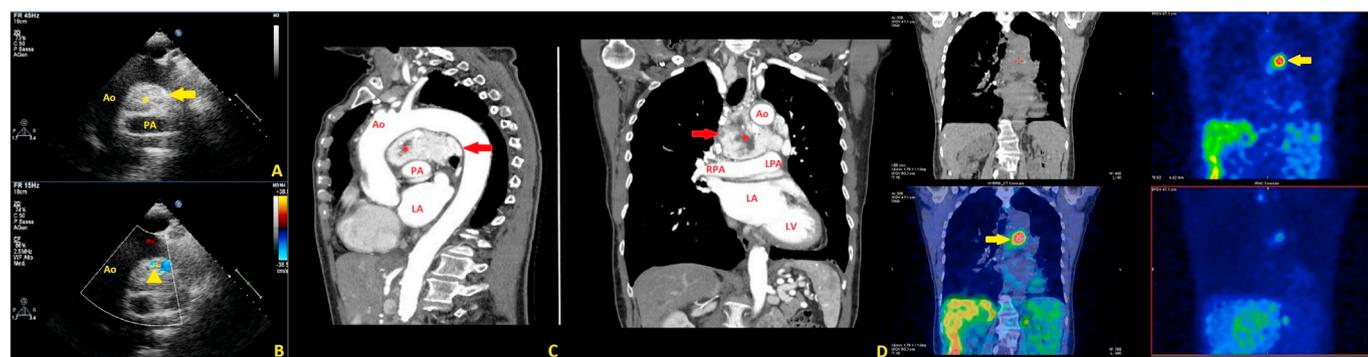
Transthoracic echo (suprasternal window) showing a hypoechoic mass (yellow arrow) with a central hyperechoic region (yellow asterisk) (A), with abundant vascularization evident with color-doppler (yellow triangle) (B). CT scan showing a contrast-enhanced mass (red arrow) with a central necrotic core (red asterisk), sagittal plane (C), frontal plane (D). Total body iodine-131 meta-iodobenzylguanidine scintillation scan with tracer accumulation in the anterior mediastinum (yellow arrow) (E). Ao = aorta; PA = pulmonary artery; LA = left atrium; LV = left ventricle; RPA = right pulmonary artery; LPA = left pulmonary artery. (For interpretation of the references to color in this figure legend, the reader is referred to the web version of this article.)
